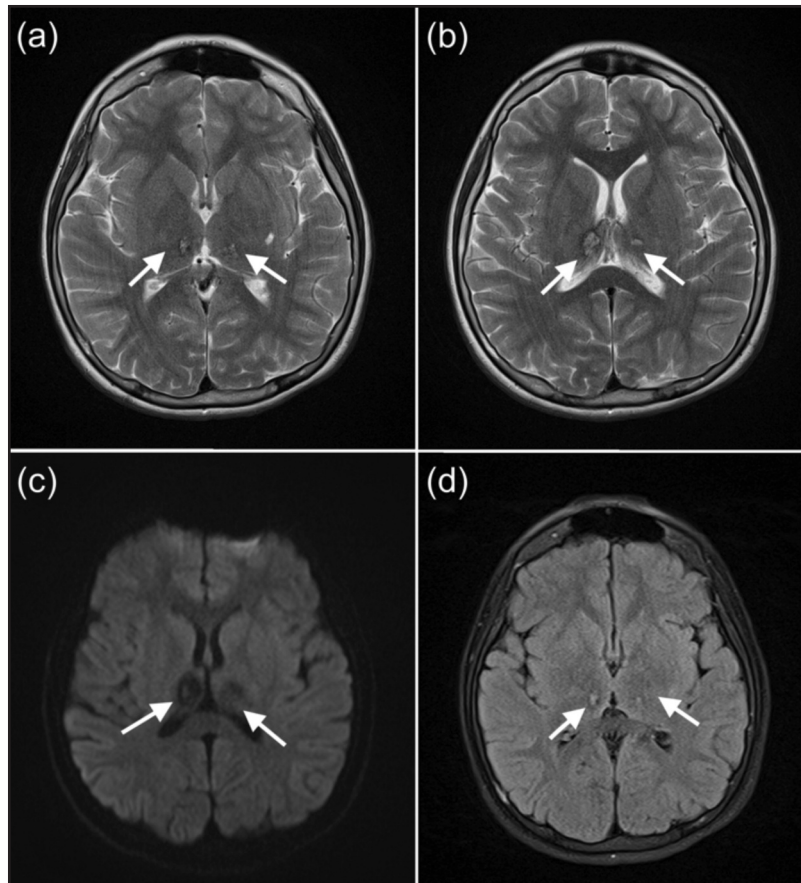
Brain MRI images of the patient that were acquired at 3 months after treatment. (a&b)
